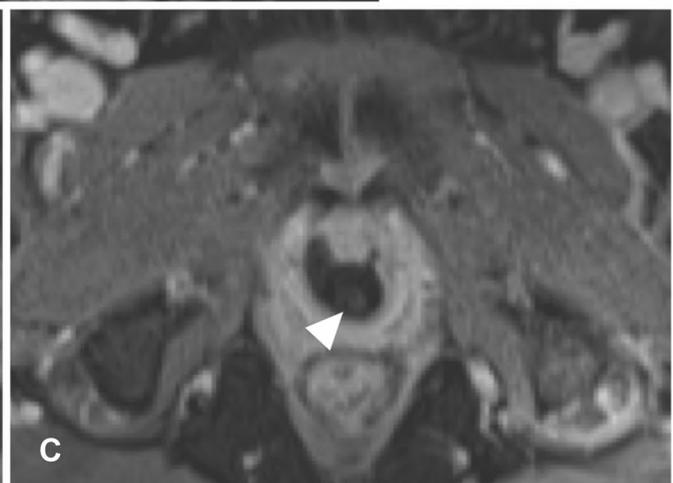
Urethral diverticulum with a thin neck and stone. a Axial T2WI demonstrates a thin neck (arrow) arising from the 1 o’clock position and a hypointense stone (arrowhead). Axial T1-weighted
